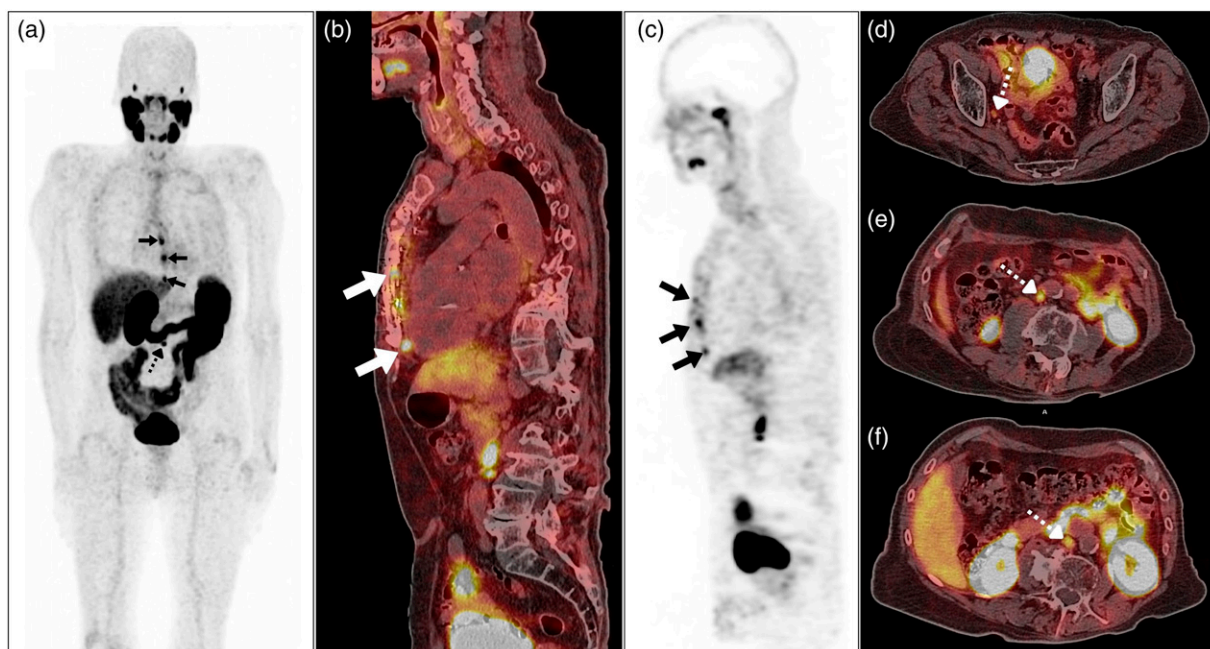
A gallium-68 prostate-specific membrane antigen (^{68}Ga -PSMA PET/CT) scan was performed for a 79-year-old man 6 months after coronary artery bypass graft (CABG) surgery. (a) Maximum intensity projection; (b) sagittal PET/CT; and (c), sagittal PET images showed multiple PSMA avid foci at the site of CABG surgical stitches with the maximum standardized uptake value (SUVmax: 11.2) (arrows). Increased PSMA expression in abdominal lymph nodes was also observed (dotted arrow). (d)-(f) Axial PET/CT images of abdominopelvic regions revealed evidence of a few PSMA-avid enlarged abdominopelvic lymphadenopathy (LAP), indicating nodal disease recurrence. These PSMA-avid metastatic LAP were found involving the right external iliac, para-aortic, and aortocaval regions, with SUVmax values of 3.6, 10.1, and 7.3, respectively (dotted arrows).
